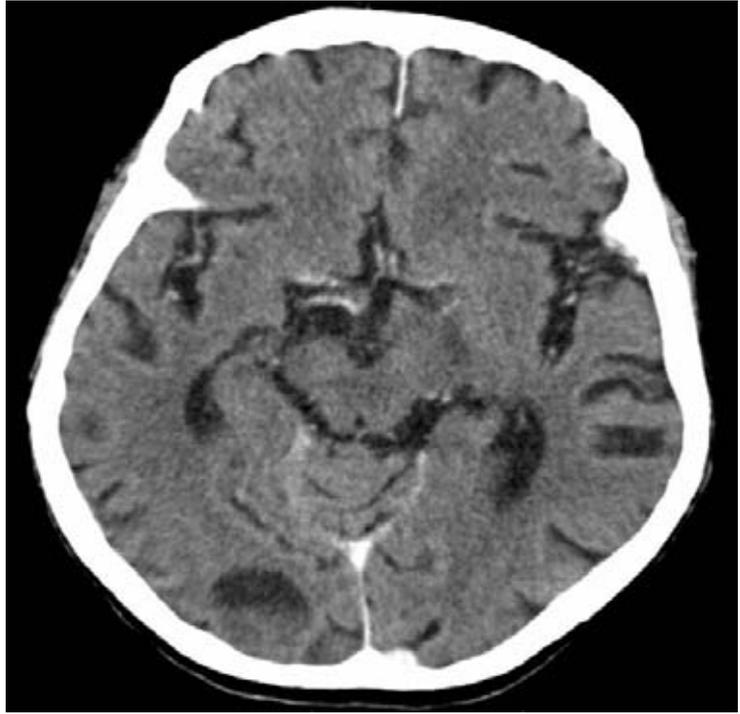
CT scan of the brain (28 December 2006).
